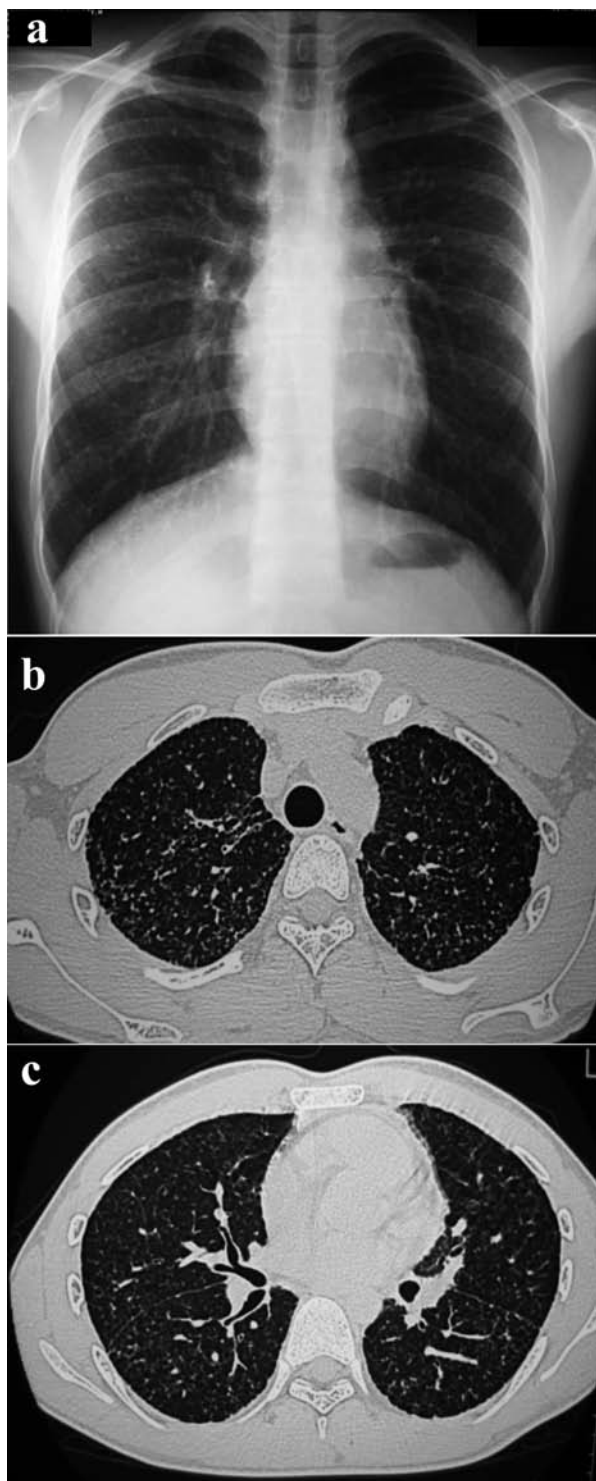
(a) Chest radiology at the age of 15 years showing small nodular shadows in the whole lung field. b and c, High-resolution CT demonstrates bilateral ground-glass attenuation with small nodules and interlobular septal thickening throughout both lungs; upper (b) and lower (c) lobes
